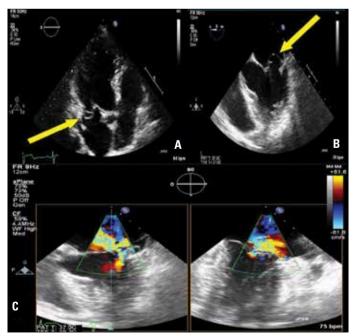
A) Apical four chamber window of TTE showing saccular aneurysm of mitral valve (arrow), B) TEE showing posterior mitral valve aneurysm. C) Transesophageal biplane color-Doppler images showing severe eccentric mitral regurgitation
